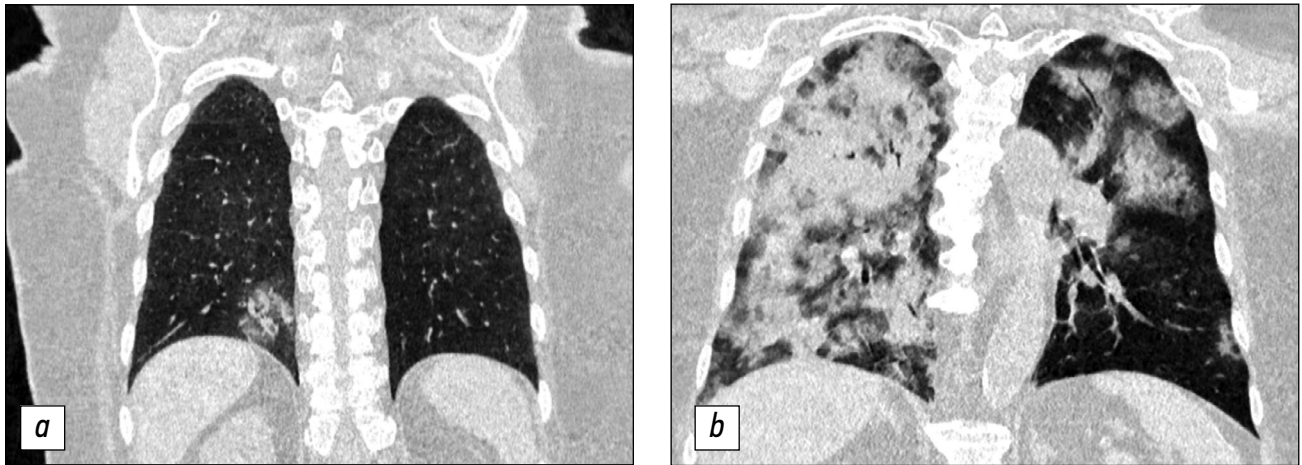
Computed tomography of the chest organs of a patient who was admitted to the hospital for the first time with complaints of dry cough and fever: *a* — in the lower lobe of the right lung, a single area of ground-glass opacity can be seen; *b* — a bilateral lesion with the involvement of more than 75% of the lung parenchyma is noted on the control image obtained after five days, with general deterioration of the condition and the emergence of severe dyspnea, corresponding to an extremely severe course of the disease.
